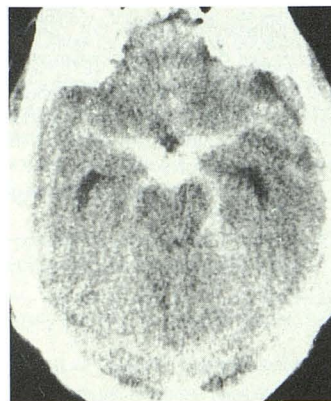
CT scan of a patient with nonaneurysmal perimesencephalic hemorrhage, mistaken for a ruptured basilar artery aneurysm.
